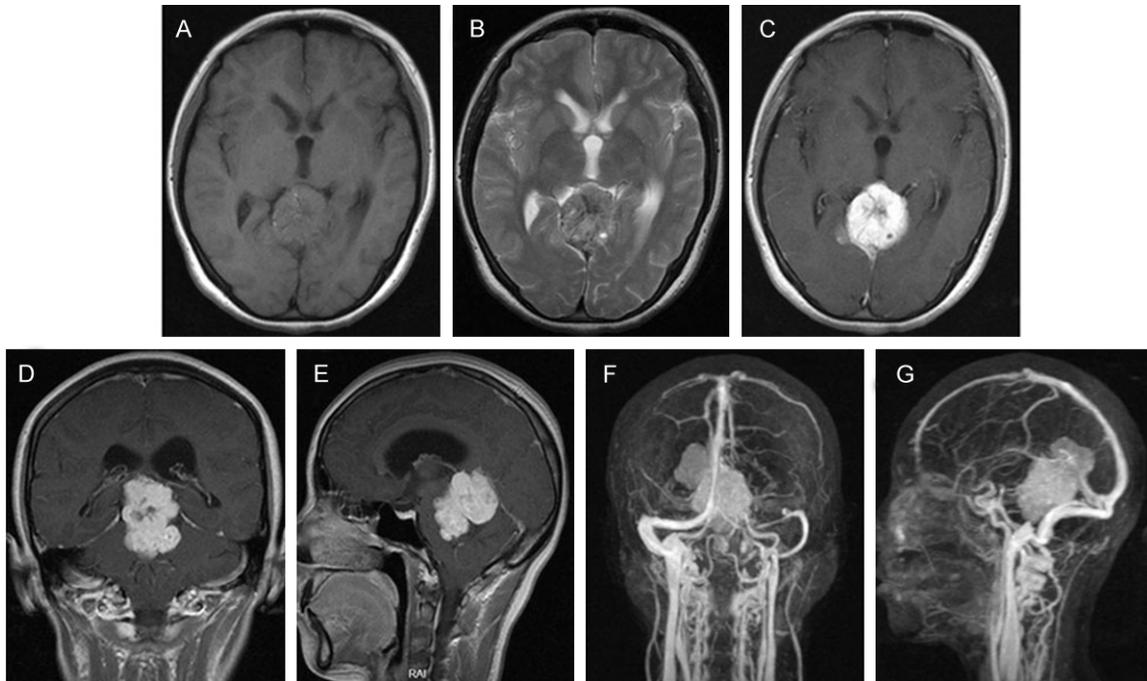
Magnetic resonance (MR) images. MRI brain show a well-defined lesion in the pineal region, isointense on axial T1-weighted image (A) and iso- to hypointense on axial T2-weighted image (B). On axial, coronal and sagittal postcontrast T1-weighted MR images, homogeneous contrast enhancement of the mass is noted (C-E), and the mass was highly vascular (F, G).
